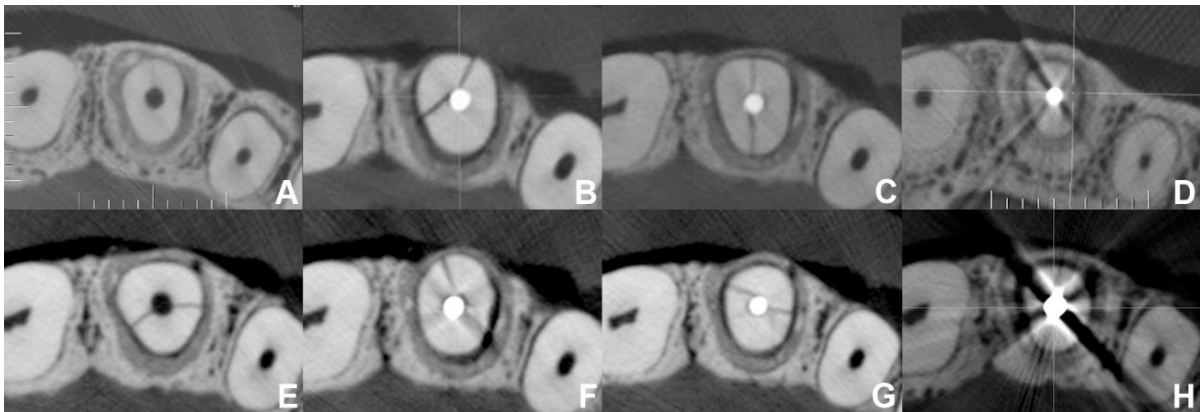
Representative images of the CBCT scans with the BAR filter, in root canals with no fillings (A), gutta-percha (B), fiberglass post (C), and metal post (D); and without the BAR filter, in roots with no fillings (E), gutta-percha (F), fiberglass post (G), and metal post (H).
